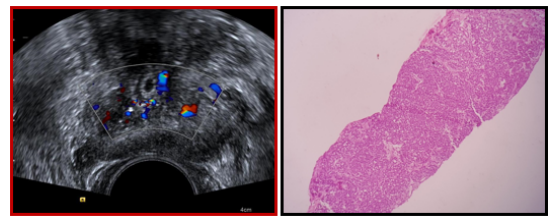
TRUS showing heterogenous pattern with increase in central vascularity on colour doppler
